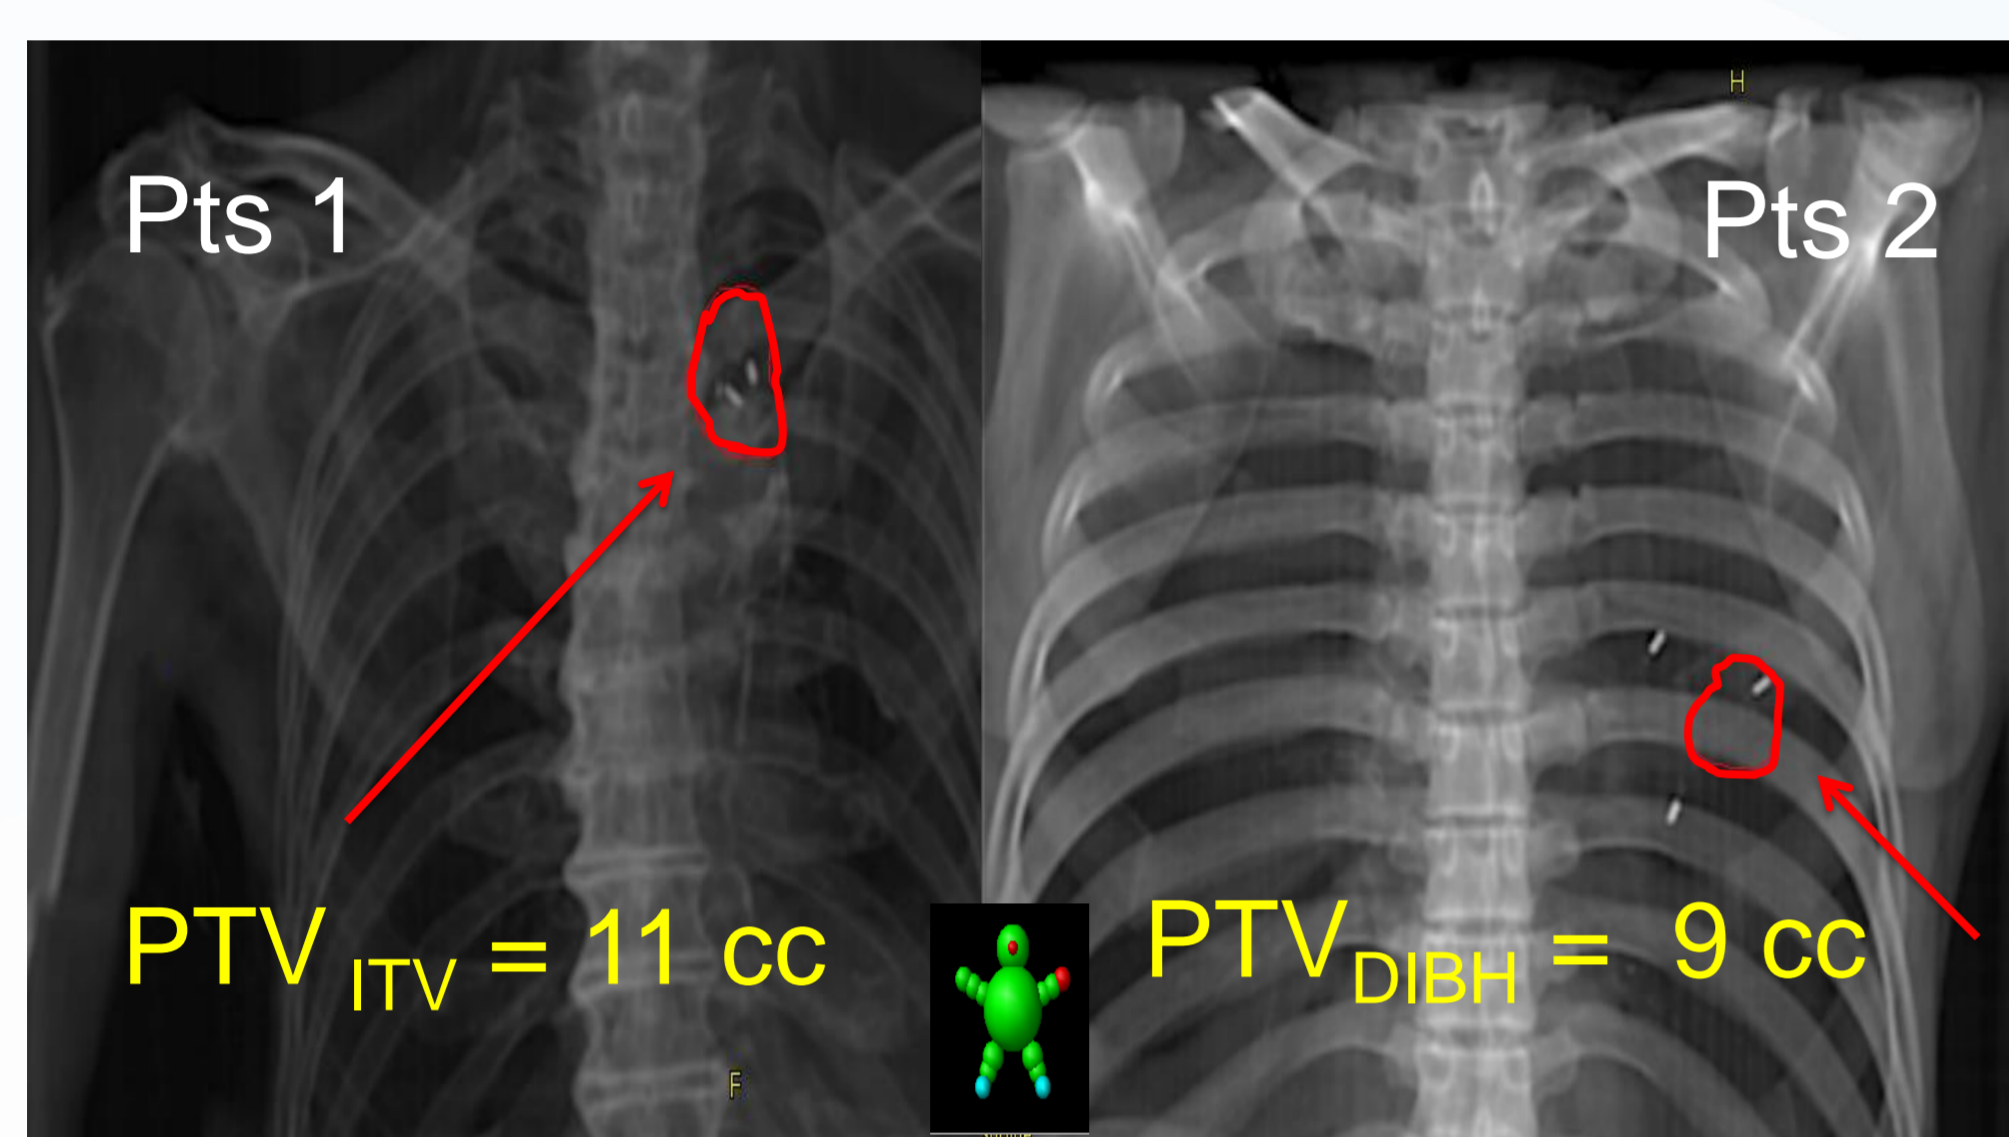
Digitally reconstructed radiographies showing EMT and planning target volumes (PTV) outlines.
